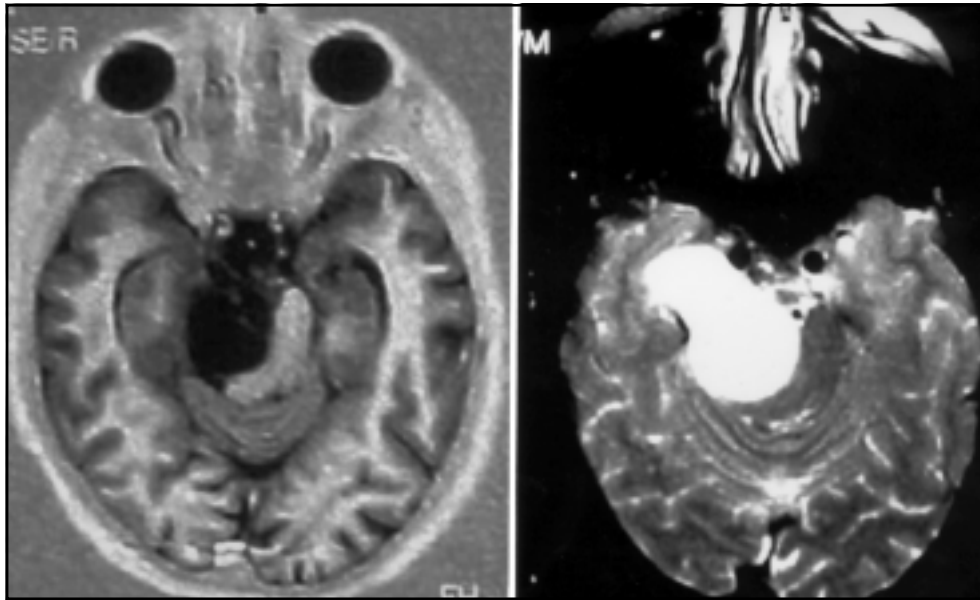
A: T1-weighted MR image showing a large lesion with hyposignal content and no contrast enhancement. B: At T2-weighted image, the hypersignal core suggests the content to be cystic.
